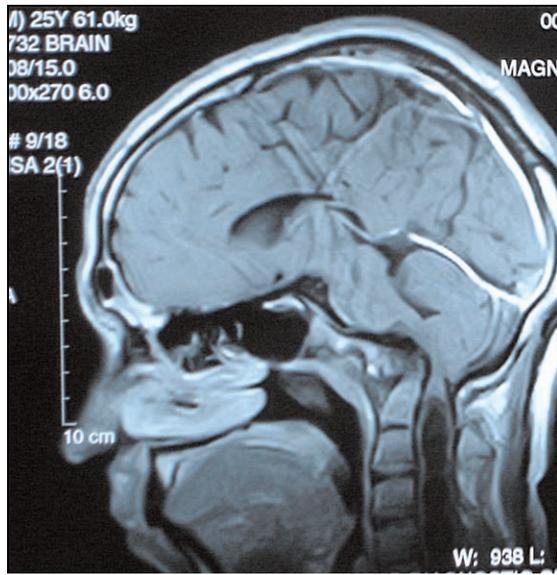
Pre-op MRI brain showing (i) basilar invagination of the odontoid process (ii) platybasia and (iii) cervical syrinx
